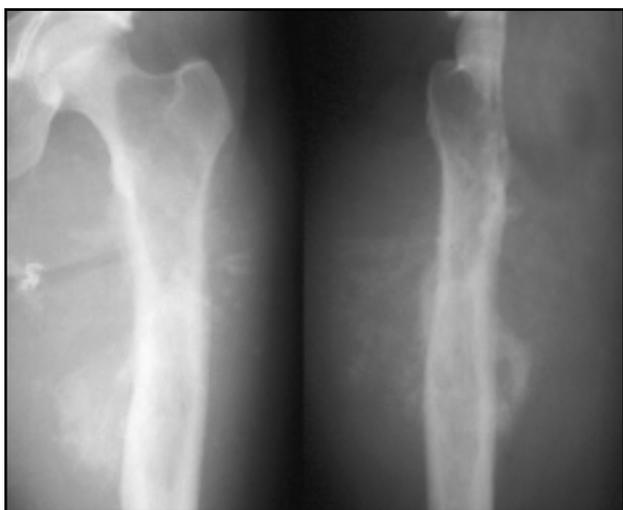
AP and lateral radiographs of the proximal femur reveal cortical destruction and a large bone lesion with soft-tissue extension and extensive spiculated periosteal reaction. (Figs 2A-C used by permission of W. G. Ward, MD.)
